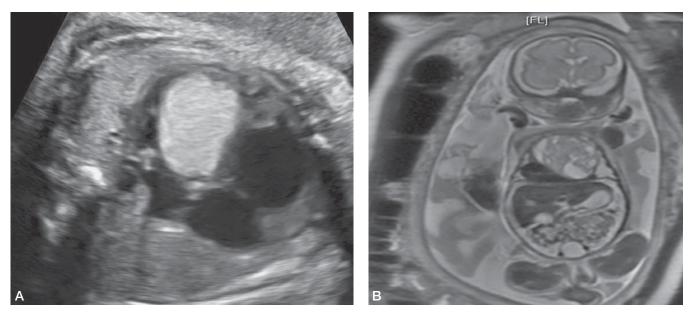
A: Antenatal sonographic image of a large intracardiac echogenic mass postnatally diagnosed as a fibroma; B shows the same mass on fetal MRI.
